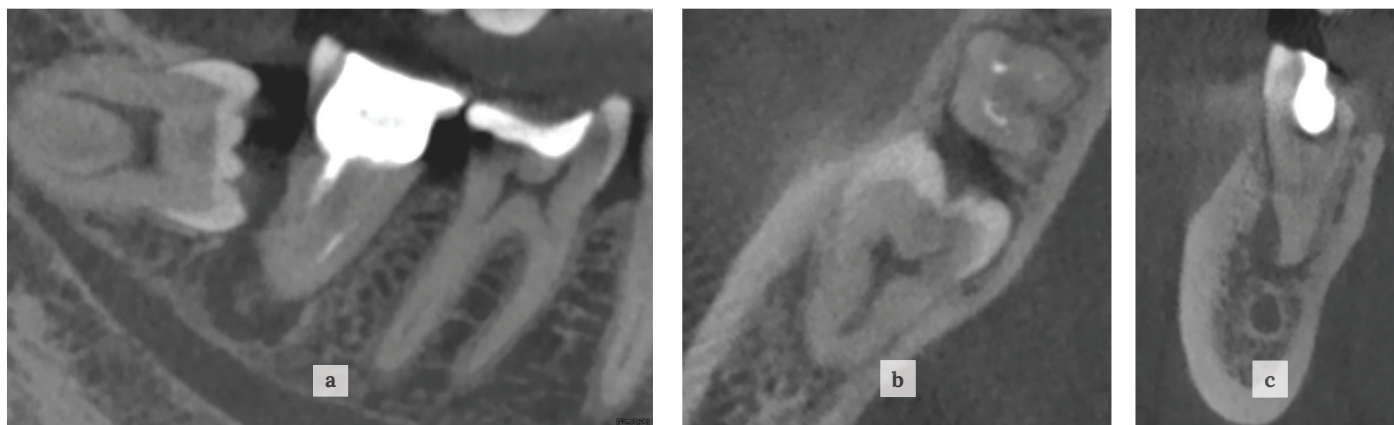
a, b, c. CBCT slices at the projection of teeth 4.6-4.8.
